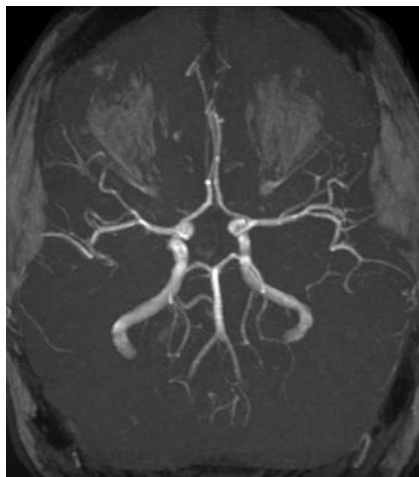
Noncontrast magnetic resonance imaging demonstrating the circle of Willis.
